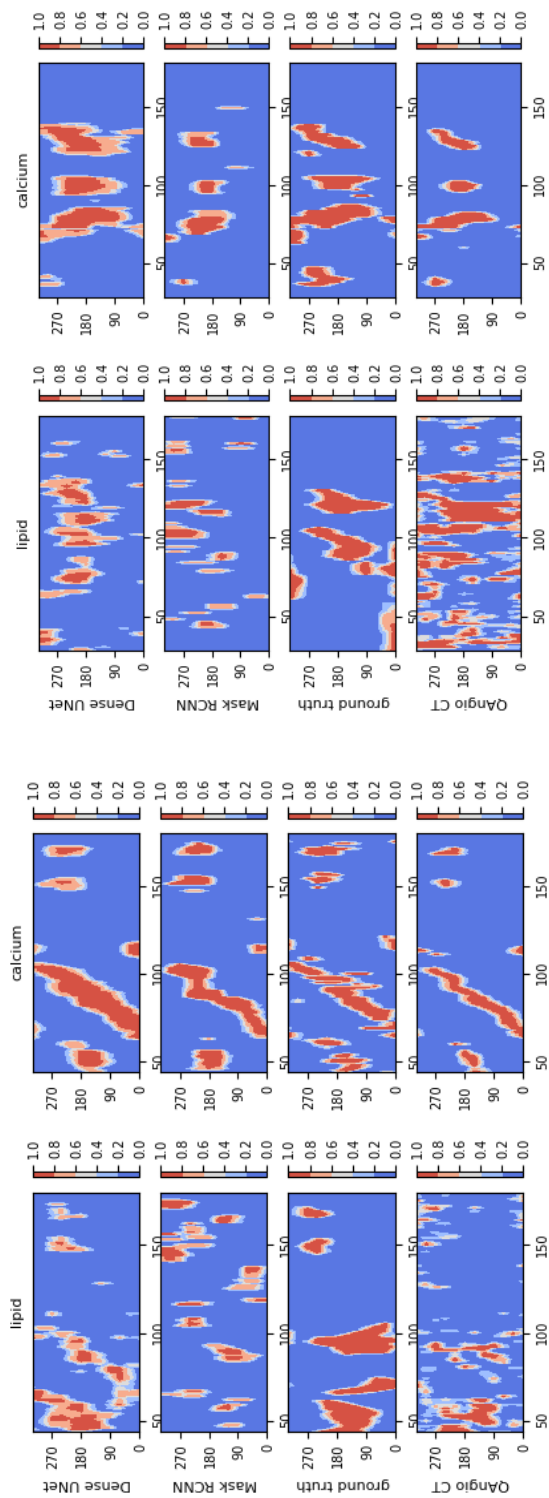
Spread-out view of lipid-rich and calcified plaques of two arteries in the test dataset. Predicted by Dense U-Net and Mask R-CNN, respectively. X-axis: indices of CT image. Y-axis: plaque occurring angle from 0° to 359° . Color bar: probability of plaque appearance from 0 to 1. (left:(a), right:(b))
